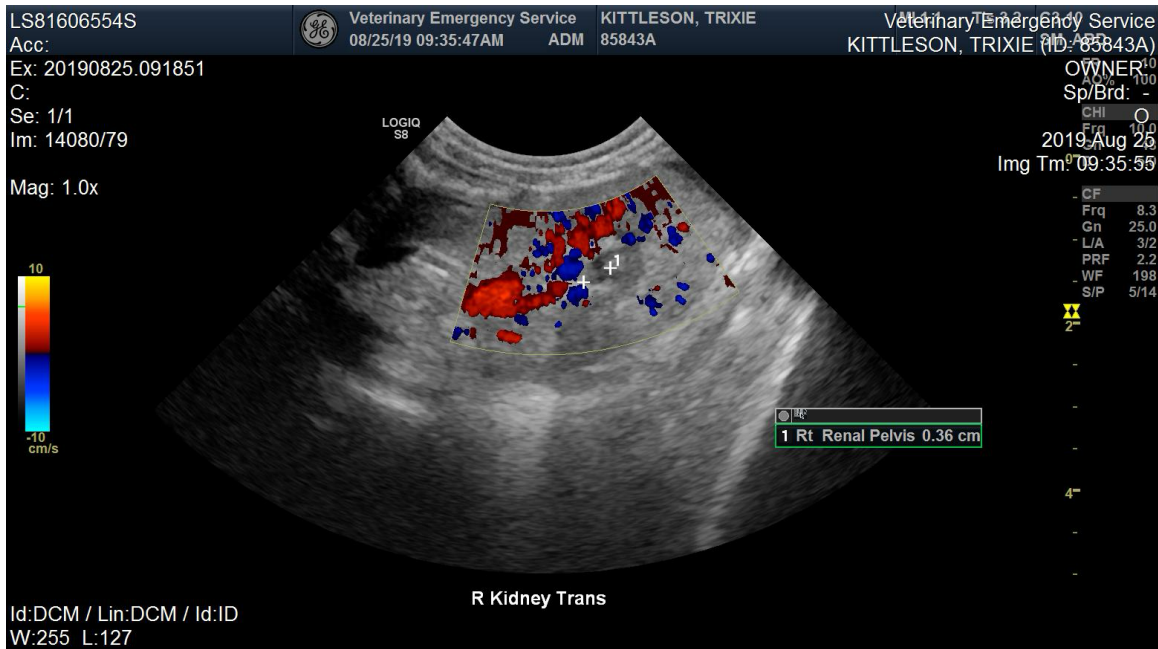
Transverse view of the right kidney. Color Doppler was used to differentiate the vasculature while identifying a dilated and hyperechoic renal pelvis (3.6 mm)
